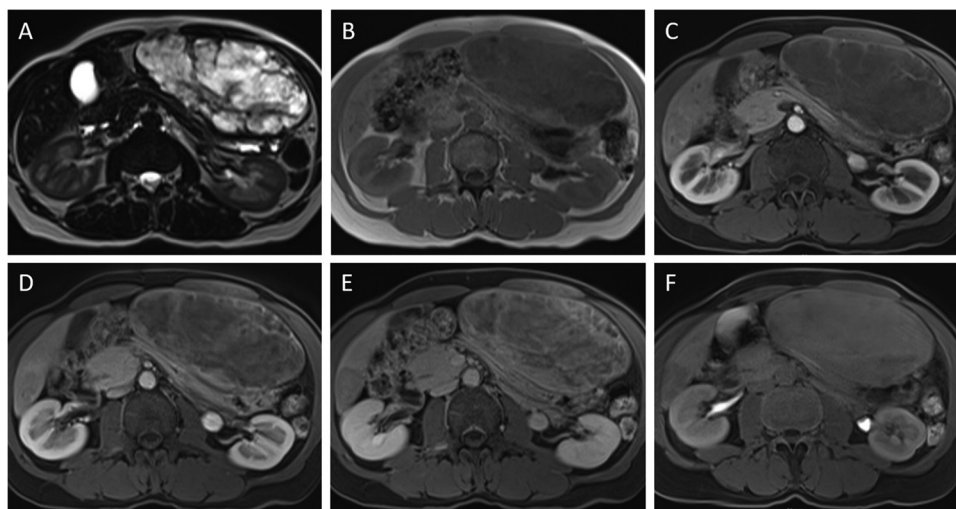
Axial MRI confirms both lesions. A. On T2-weighted imaging, the left-sided lesion demonstrates marked hyperintensity with interspersed bands of lower signal intensity, while the right-sided lesion is discretely hyperintense to the adjacent liver parenchyma, with a central punctiform area of marked hyperintensity. B. On T1-weighted imaging, the left-sided lesion is markedly hypointense, while the right-sided lesion is discretely hypointense to the surrounding liver parenchyma, with a central punctiform area of marked hypointensity. C–E. Arterial, portal venous and delayed phase dynamic contrast-enhanced fat-saturated T1-weighted images with gadobenic acid (Gd-BOPTA) demonstrate heterogeneous, centripetal-predominant arterial enhancement that progressively and more homogeneously enhances on later phases in the left-sided lesion. The right-sided lesion remains hypointense to normal liver parenchyma in all phase, with progressive enhancement of the central punctiform area. F. 90-minute hepatobiliary phase image demonstrates absence of contrast retention within the lesions, indicating absence of normally functioning hepatocytes and/or bile ducts.
